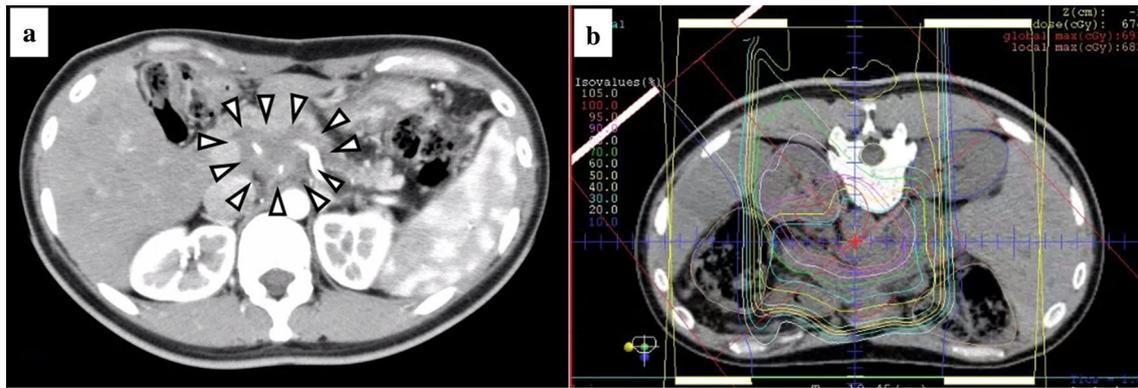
a Contrast-enhanced computed tomography of the isolated local recurrence after pancreatoduodenectomy for pancreatic ductal adenocarcinoma. b Proton radiotherapy treatment planning for
